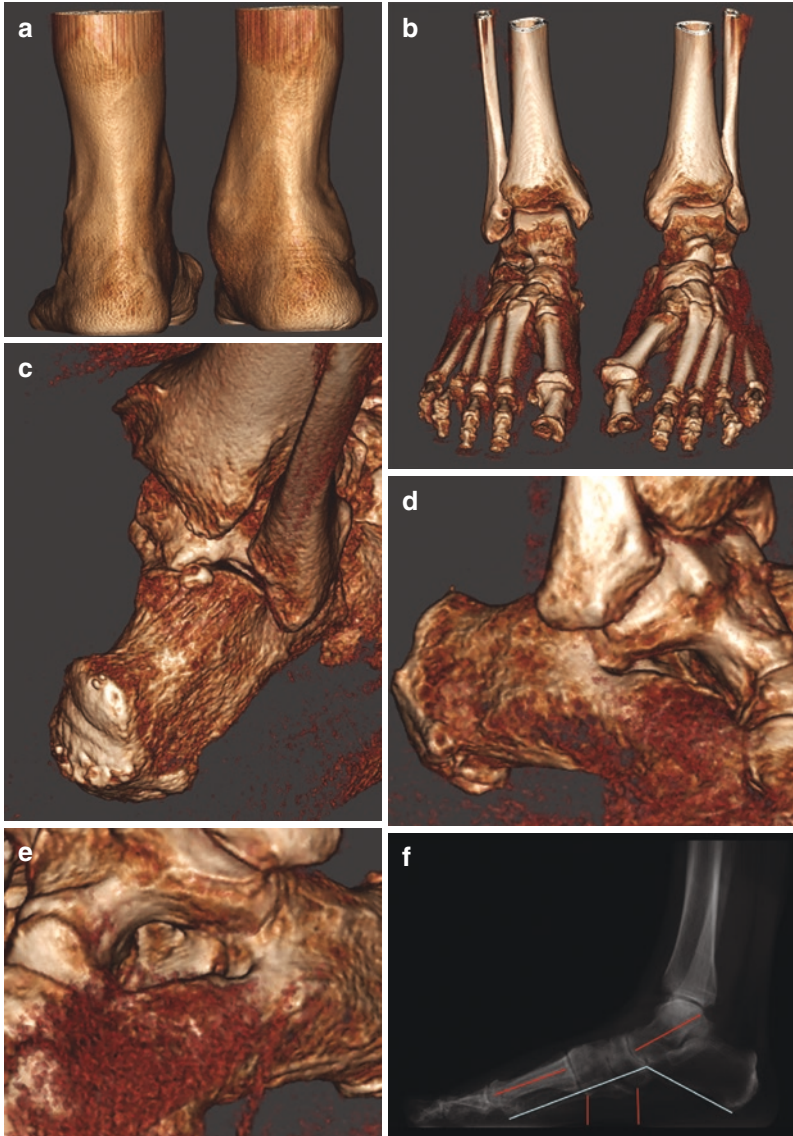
Shows a posttraumatic case of acquired flatfoot following chronic subluxation of the tibialis posterior tendon. The bilateral posterior skin view shows deviation of the hindfoot (a). The AP 3D rendering bone view shows lateralization of the forefoot and plantar drop of the talus comparative to the asymptomatic side (b). We have added a posterior 3D bone view showing the enlarged medial groove consequence of chronic subluxation of the posterior tibial tendon (c). (d, e) show the talocalcaneal lateral impingement in the sinus tarsi on the symptomatic (d) and asymptomatic (e) sides. Conventional measurements are possible very rapidly using pre-programmed and readily available DRR (digitally reconstructed radiographs) incidences such as this lateral 2D view (f) showing medial arch angle, Meary's angle, and navicular and medial cuneiform to floor distances. The TALAS (g) window shows the result of the semiautomatic hindfoot alignment software. In this case, the foot ankle offset value is 10.8%, advocating for a severe case of flatfoot
